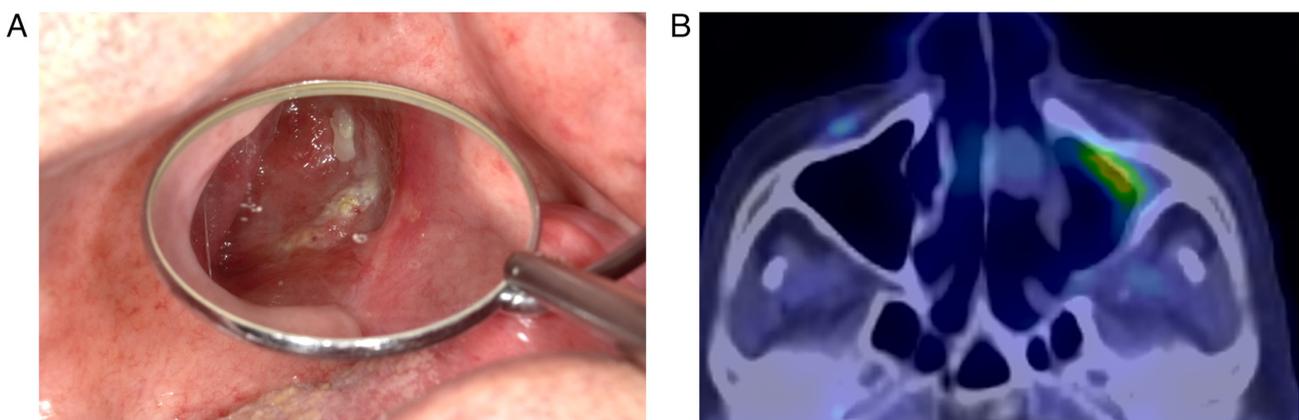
Recurrent lesion observed 10 months after the completion of bioradiotherapy. (A) An erosive lesion was observed in the anterior wall of the left maxillary sinus. (B) FDG positron emission tomography shows a high uptake of FDG in the same area. FDG, 18-fluoro-2-deoxyglucose.
